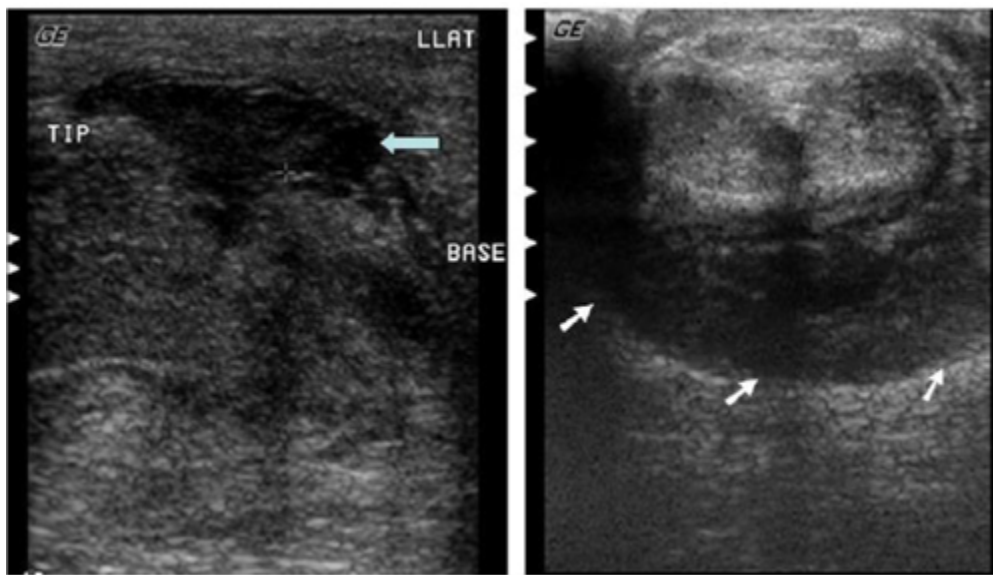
Ultrasound imaging showing an albugineal tear (on the left, see arrow) and penile haematoma encircling the shaft (on the right, see arrows). *Source:* Adapted from Shenoy-Bhangle A, Perez-Johnston R, Singh A. Penile imaging. *Radiol Clin North Am.* 2012 Nov;50(6):1167-81. doi: [10.1016/j.rcl.2012.08.009](https://doi.org/10.1016/j.rcl.2012.08.009). PMID: 23122044. [↩](#)
